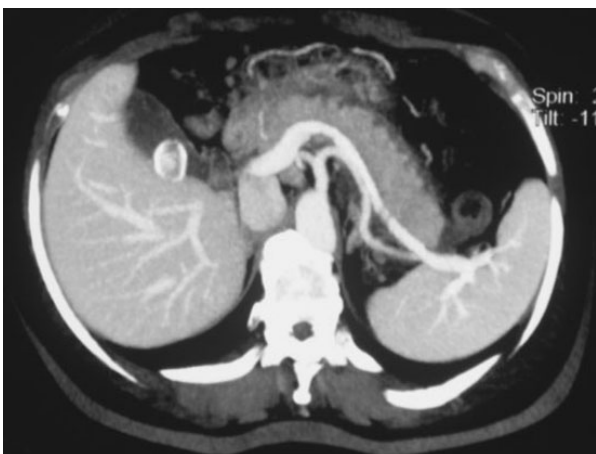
Multidetector computed tomography scan: stranding during an acute pancreatic inflammation.
